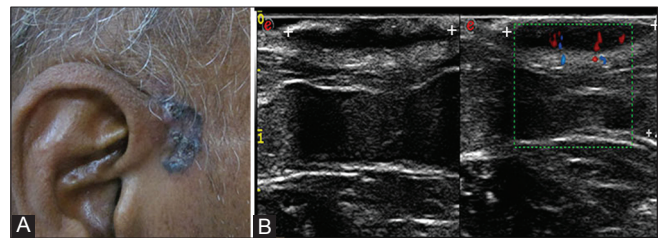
(A) Basal cell carcinoma on face, seen as pigmented nodular lesion with rolled-up margins. (B) HRUS shows irregular, hypoechoic, heterogeneous lesion in the dermis, with posterior shadowing and intralésional vessels on Color Doppler
